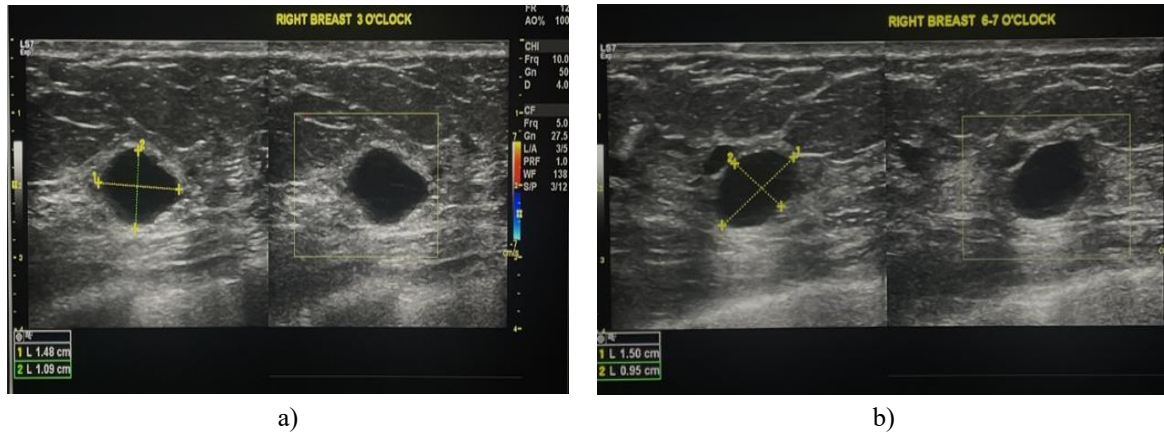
Ultrasonographic imaging of the right breast revealed several cystic formations, the largest measuring approximately 1.5 by 1 cm; these cysts exhibited sharply demarcated margins and thin walls; a number of them contained fluid with visible debris layering, though no internal mural nodules were observed within any of the lesions.
